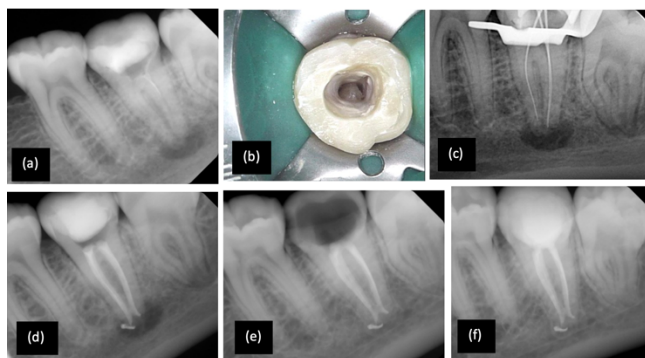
A 23-year-old female were referred to an endodontics clinic to continue the root canal treatment (RCT) of tooth #37 due to its difficult morphology. (a)Pre-operative radiograph. (b)
